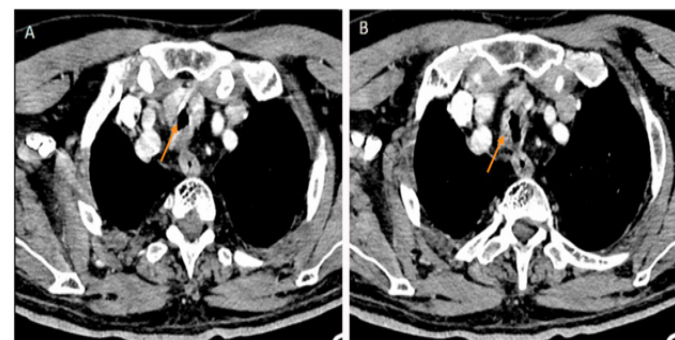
CT scan findings for Case 2. A significant tracheal stenosis after 2 months of intubation due to SARS-CoV-2 infection (A, B arrows).⁷
